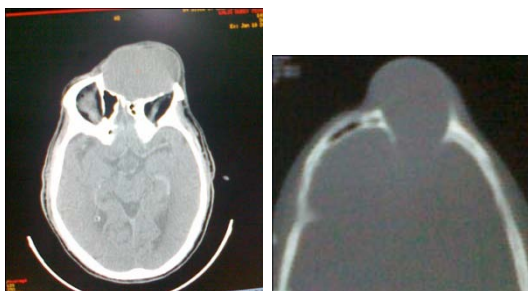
CT scan (a) axial cut brain and (b) bone window: a giant right frontal mucocele
